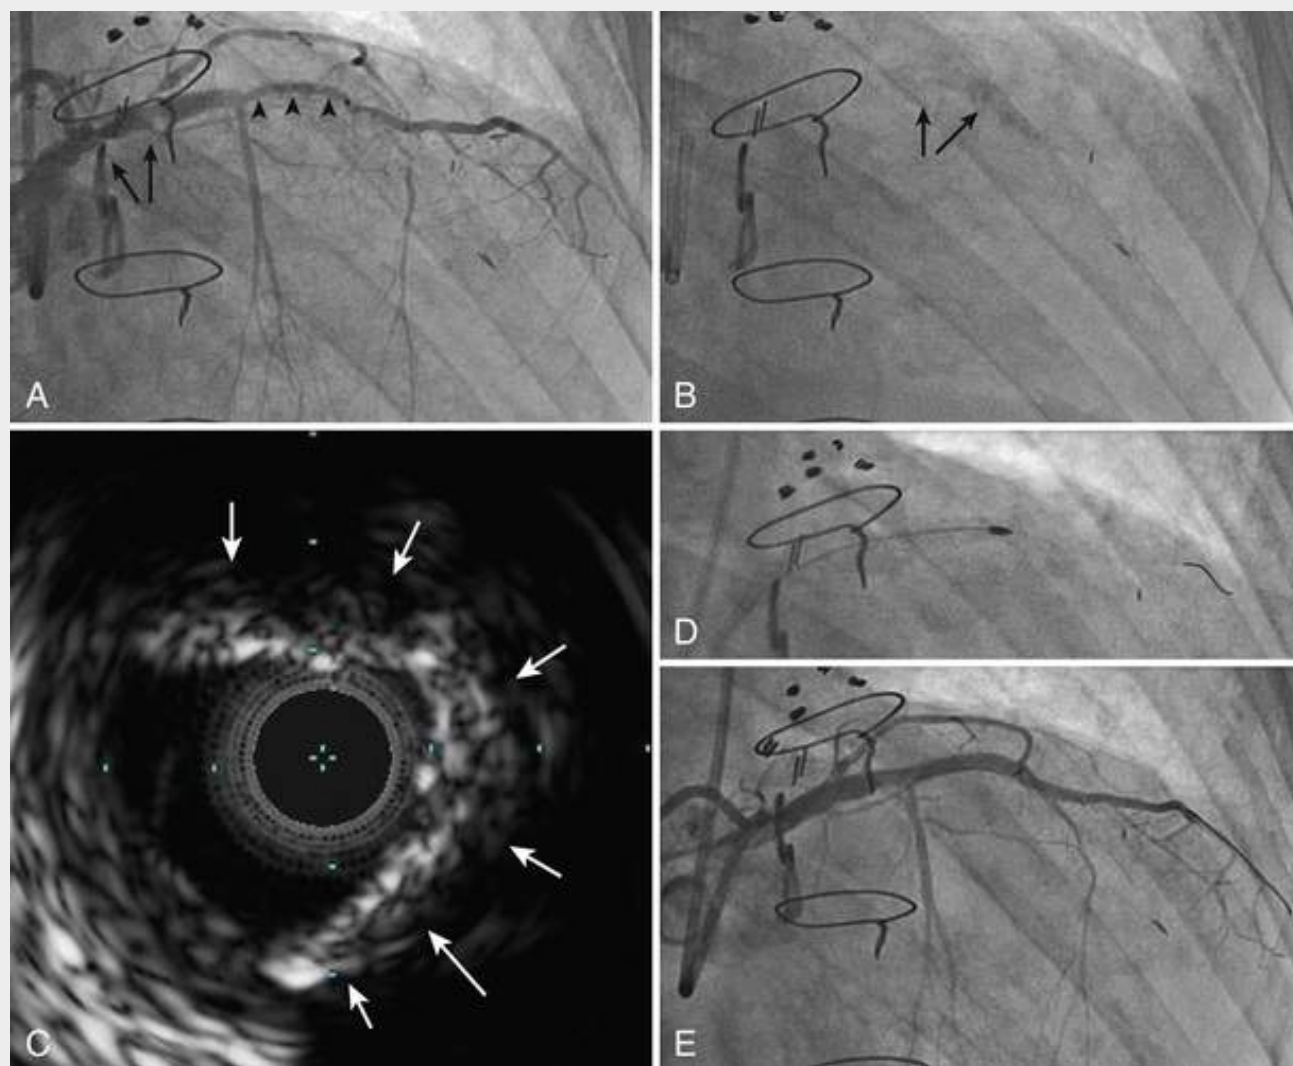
Rotational atherectomy of the left anterior descending coronary artery (LAD)/diagonal. A, Initial angiogram demonstrates severe calcified stenosis in the proximal (*arrow*) and mid-LAD (*arrowheads*) extending to the diagonal. B, Fluoroscopy alone shows the severe calcification (*arrows*). C, Intravascular ultrasound demonstrates 270-degree calcification (*arrows*) with echo dropout behind the calcium. D, Rotaburr in the mid-LAD. E, Final angiogram after stent placement. (From Krishnaswamy A, Whitlow PL. Calcified lesions. In Bhatt DL, editor. *Cardiovascular Intervention: A Companion to Braunwald's Heart Disease*. Philadelphia: Elsevier; 2016.)
